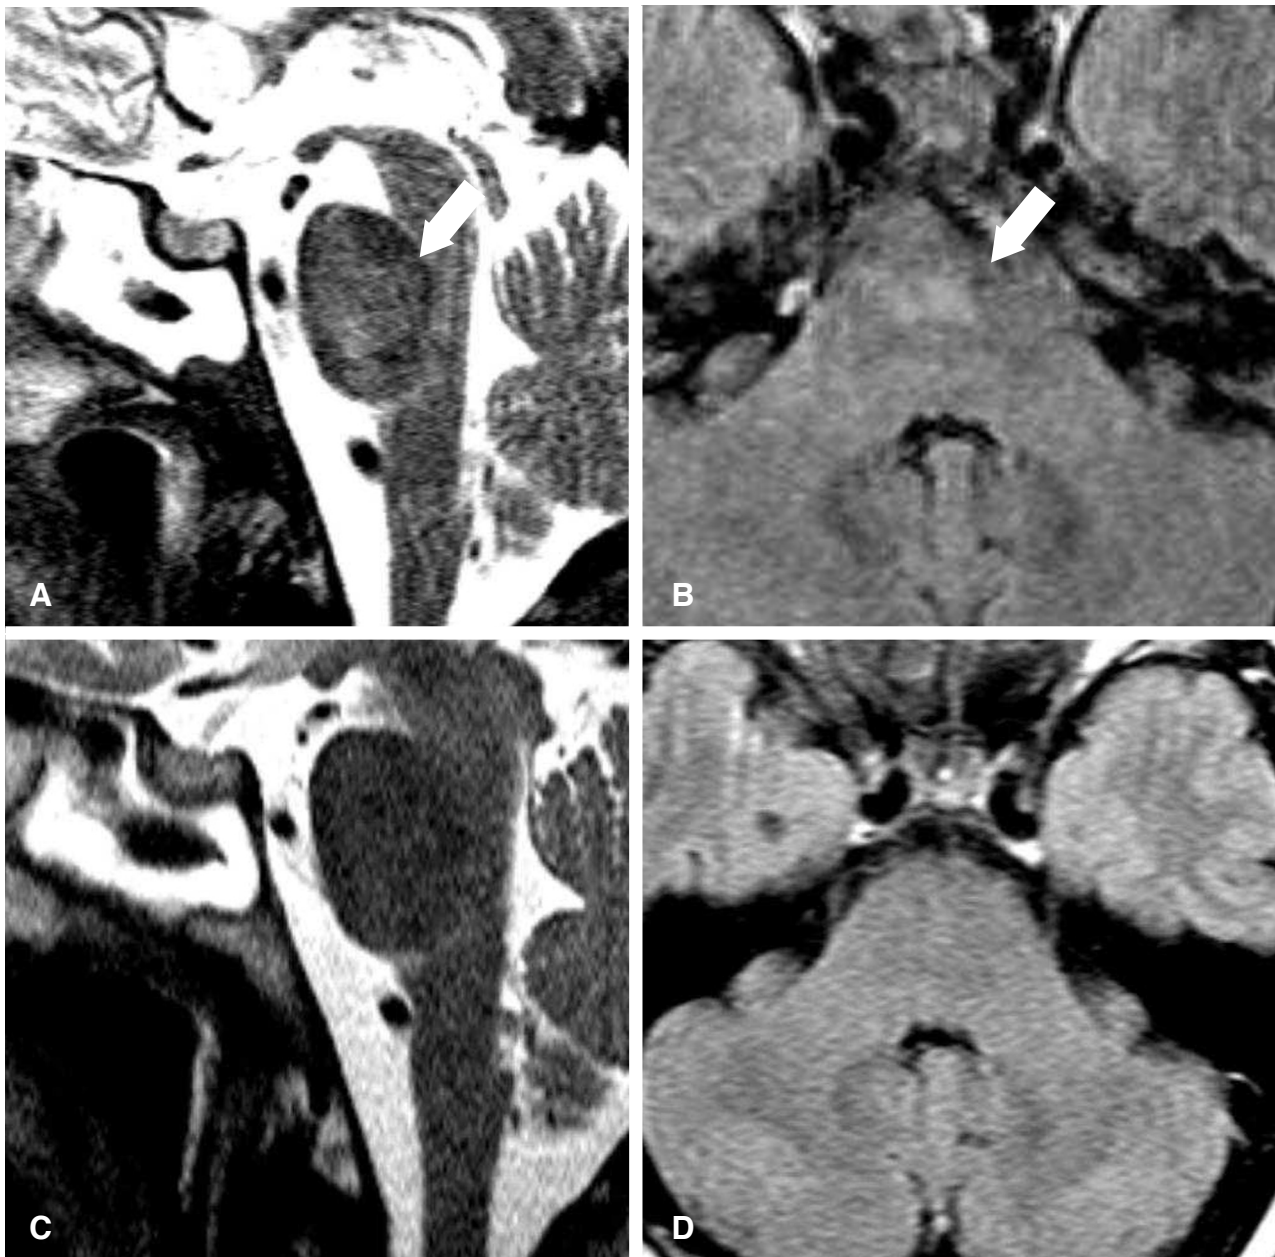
Signal enhancement (see arrow) in the medullo-pontine region. A: transversal reconstruction, B: sagittal reconstruction before treatment. C,D: on control MRI nine months later the pathological enhancement has resolved.
